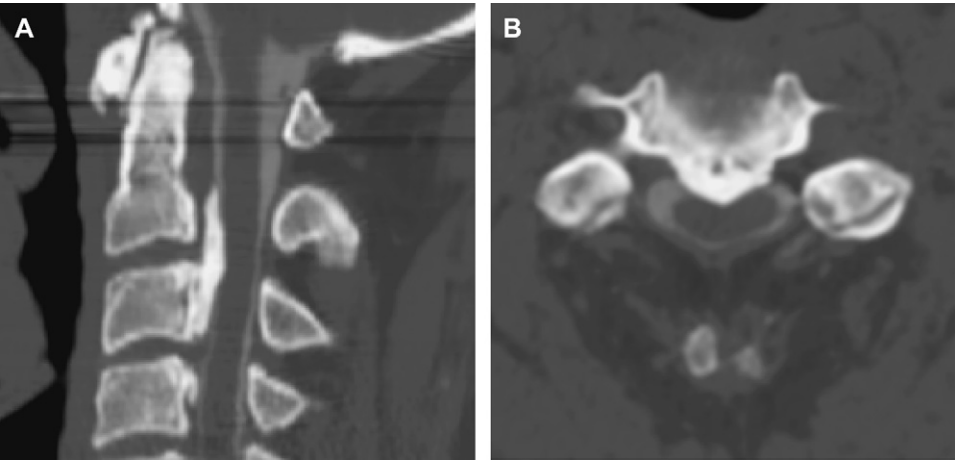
Sagittal (A) and axial (B) CT scans reveal continuous segmental OPLL at C2 to C3 (with en bloc ossification of dura at C3).
